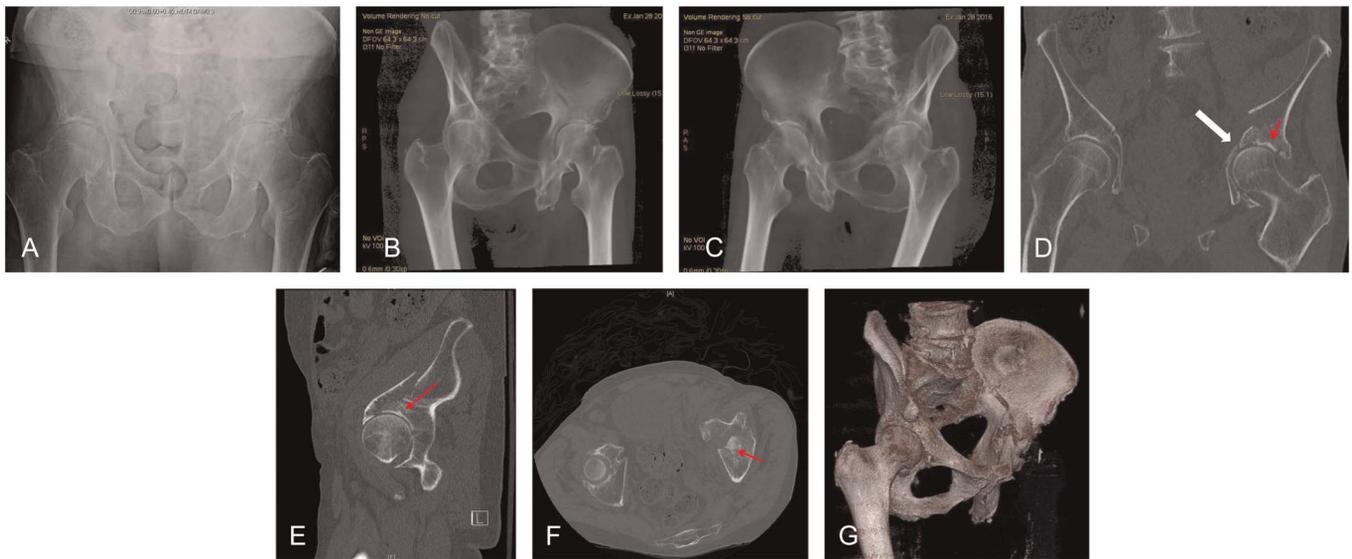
A, Injured anteroposterior pelvis radiograph. B, Injured left iliac oblique radiograph volume-rendered reconstruction. C, Injured left obturator oblique radiograph volume-rendered reconstruction. D, Injured coronal reformats of computed tomography scan demonstrating medialization of the femoral head and comminuted quadrilateral surface (white arrow) with superior dome impaction (red arrow). E, Injured sagittal reformatted computed tomography demonstrating the displaced anterior column and impacted dome segment (arrow). F, Injured axial computed tomographic image demonstrating the anterior column fracture line and impacted articular segment involving the dome (arrow). G, Injured surface-rendered computed tomographic image demonstrating the disrupted anterior column and quadrilateral surface with intact posterior column.
